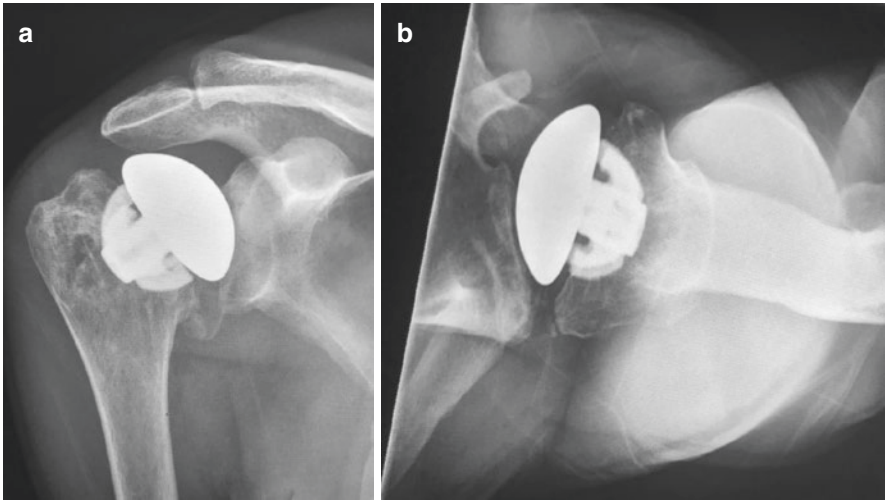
X-rays showing hemiarthroplasty of the shoulder
